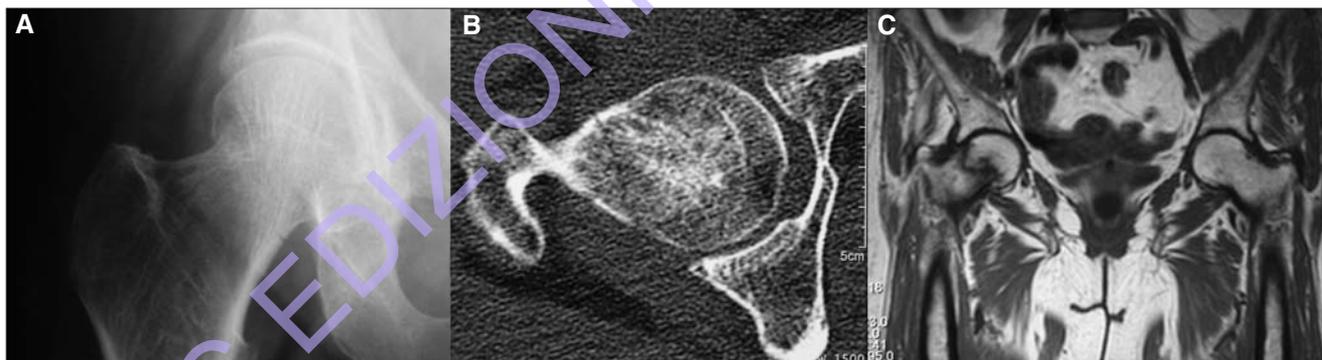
Femoral neck fracture seen with X-rays (A), more evident in 3D techniques: CT (B) and MR (C).
